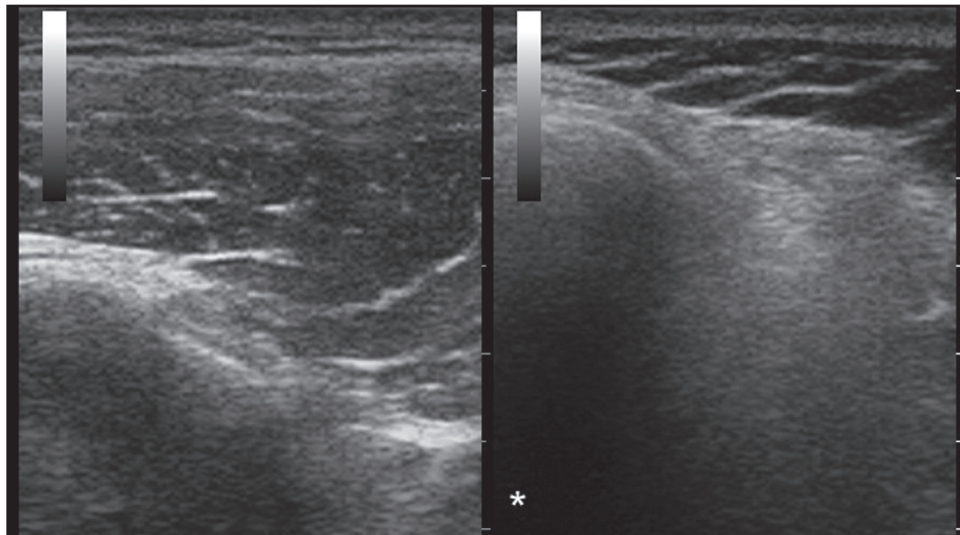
Musculoskeletal Ultrasound scan. Subject 2: transverse scan (patient seated, probe placed laterally to shoulder convexity) showing the increase in the echogenicity of the right anterior deltoid muscle (*) with reduction of the thickness with respect to the contralateral.
